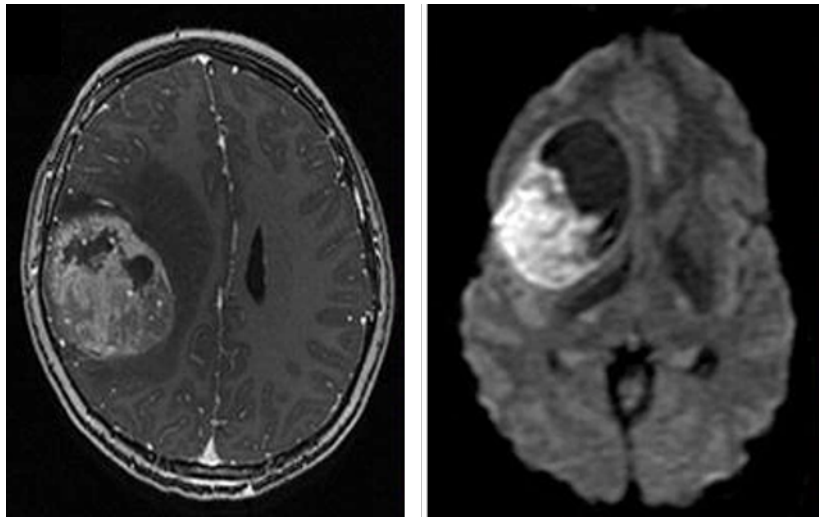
Representative MRI images of GBM. Figure adapted from Louis et al.⁵
